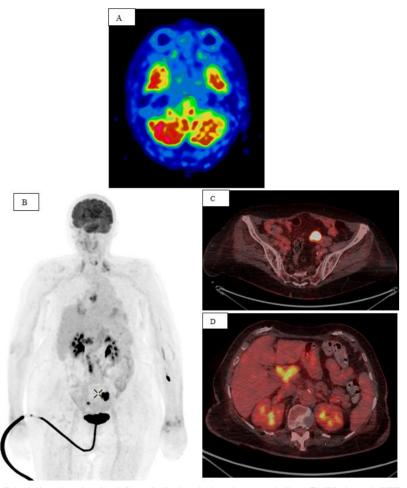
A) PET-CT ¹⁸F-FDG brain imaging showing left cerebellar hemisphere hypometabolism; B) Whole body PET-CT ¹⁸F-FDG showing bilateral adnexal tissue masses hypermetabolism, (C) left ovary showed in axial section) along with retroperitoneal, hepatic hilar, (D) also showed in upper abdominal axial section), mediastinal and bilateral supraclavicular lymphadenopathies; of note, increased uptake at the level of the writs suggestive of inflammation.
